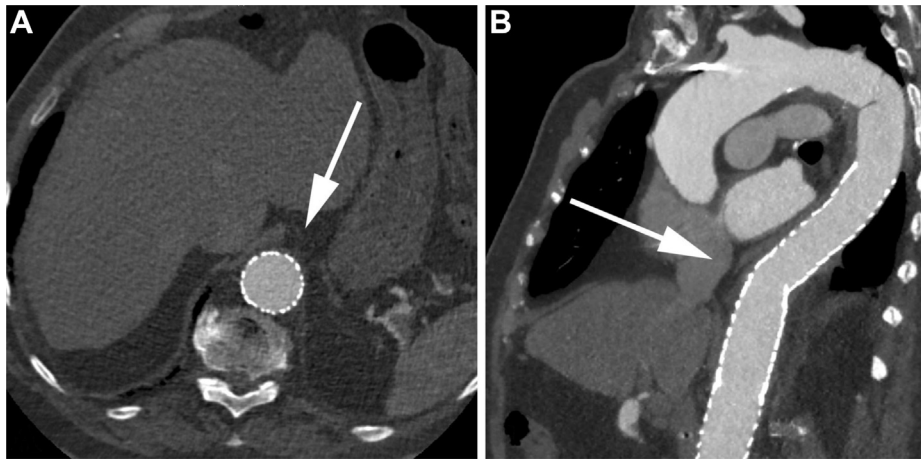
Computed tomography angiography (CTA) images at 3-year follow-up showing complete resolution of inflammation and infection. A, Axial image at level of distal thoracoabdominal graft. B, Candy cane digital reconstruction.
